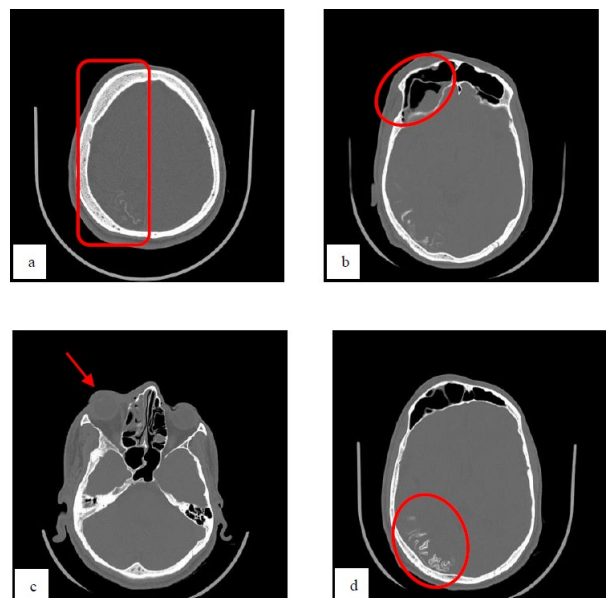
Computed Tomography – Axial Sections of Brain (a) cerebral hemiatrophy with calvarial thickening (b) polypoidal thickening in the right frontal sinus (c) protrusion of the right eyeball (d) Cortical and sub-cortical tram track like calcifications.
